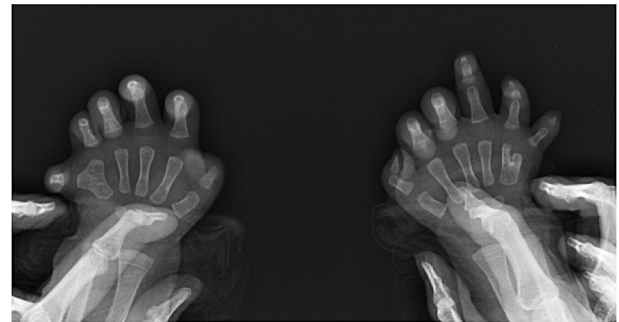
Neonatal X-ray of bilateral hands with postaxial polydactyly (PAP).
